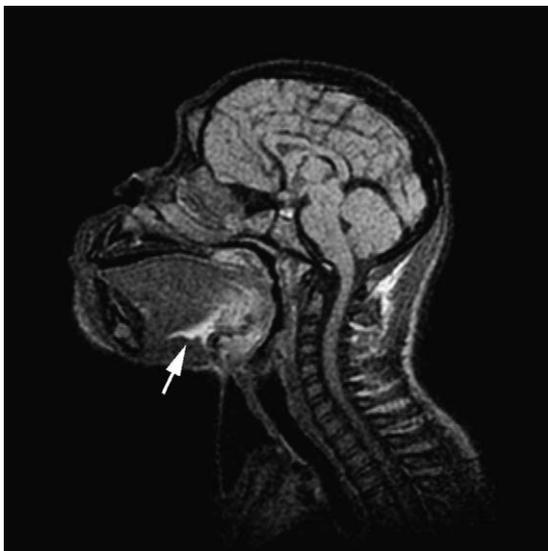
MRI scan of Ayumu at 52 months of age. When capturing the image the tongue was contracted and the hyoid was pulled antero-superiorly. This is shown by the deformed connective tissue between the *genioglossus* and *geniohyoideus* muscles (arrow; white tissue on the image), compared with the images of Figure 1.
